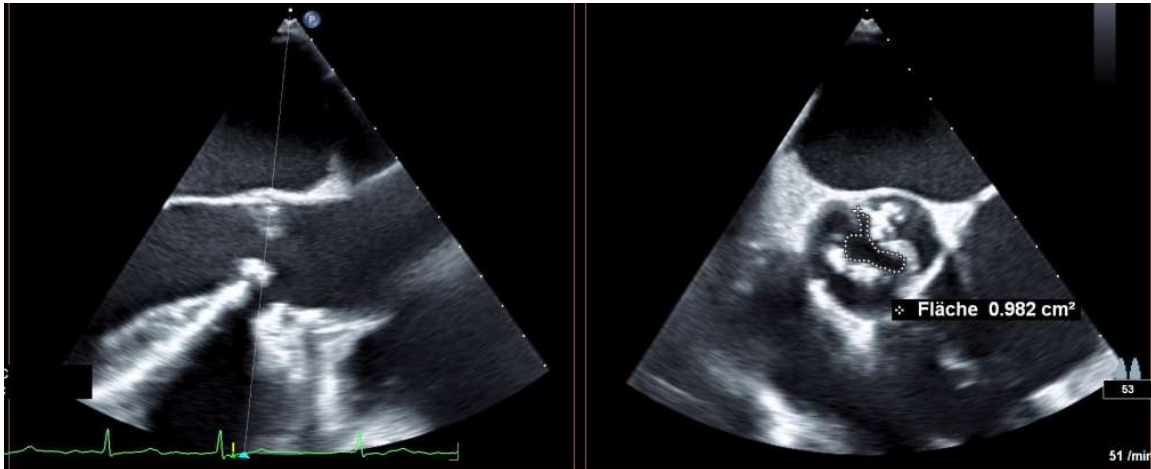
Significant aortic stenosis detected by transesophageal echocardiograms. The axial view in the left-hand panel demonstrates symmetrically thickened and calcified leaflets that have a reduced excursion, and the right panel demonstrates a reduced aortic valve area of ca. 1 cm², demonstrated: diagnosis and treatment, adapted from Larson JM (6).
